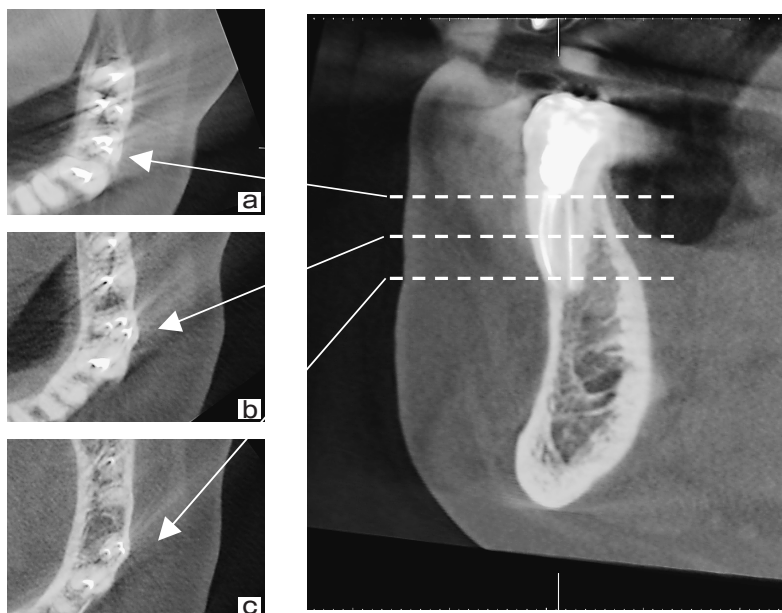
Five-year follow-up cone-beam computed tomography (CBCT). Left, an axial view from the floor of the pulp chamber to the apical third of the tooth; a, The entrances to the 3 independent root canals can be seen around the beginning of the middle third; b, Three separate root canals can be seen at the middle third of the tooth; c, Note that the mesiobuccal and distobuccal root canals appear to approach each other at the apical third of the tooth; Right, a sagittal view of the tooth.
